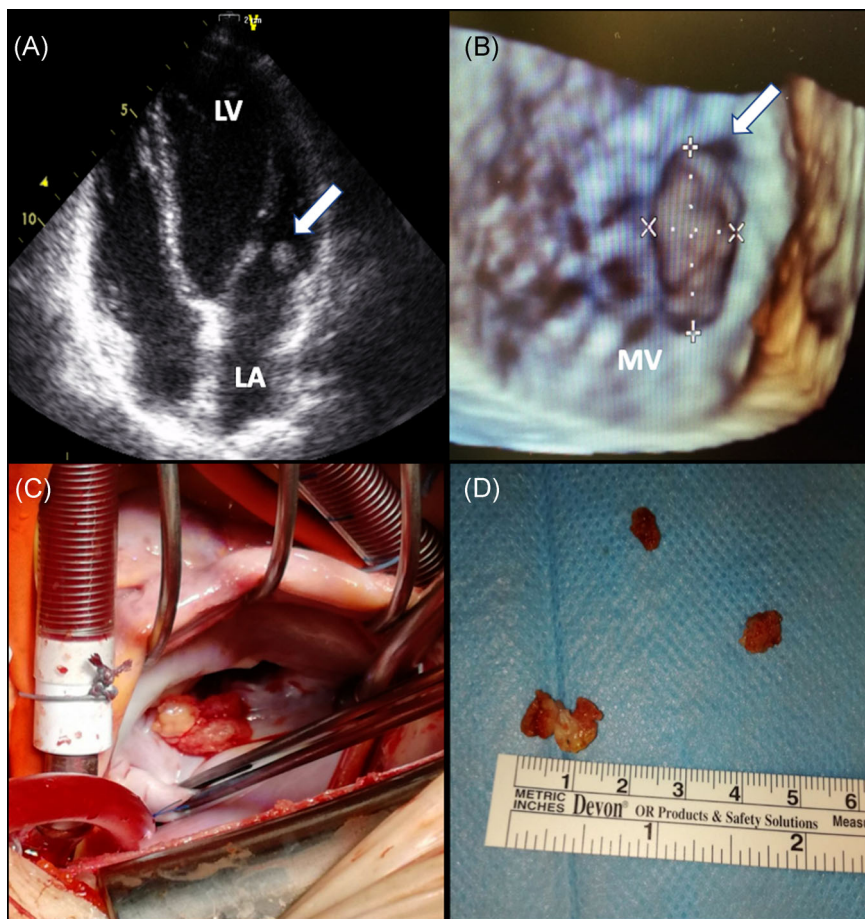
A, Transthoracic echocardiography demonstrated a mobile mass attached to the posterior leaflet of the mitral valve (arrow). B, Three-dimensional intraoperative transesophageal echocardiography confirming previous details. C, Intraoperative view of the mass after left atriotomy. D, Gross appearance of the mass with an encapsulated, solid, jelly-form structure, appearing as a pale thrombus. LA, left atrium; LV, left ventricle; MV, mitral valve
